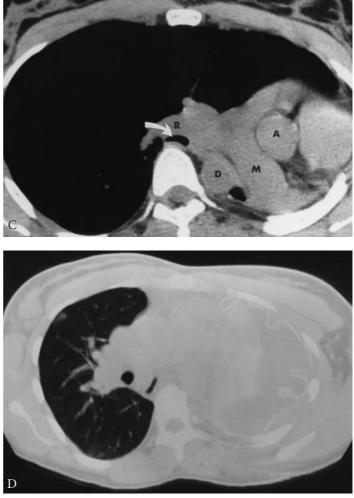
(CONTINUED) Postpneumonectomy syndrome in a 26-yearold woman, 14 years after a left pneumonectomy in the presence of a normal left-sided aorta. Short carinal resection had also been necessary. Dyspnea was of 3 years duration. C, Computed tomography (CT) scan shows the bronchus intermedius (arrow) compressed against the vertebra. A = ascending aorta; D = descending aorta; M = main pulmonary artery; R = right pulmonary artery. D, CT scan after corrective surgery. Lung volume is returned to normal and the main bronchus is on the right of the spine.
